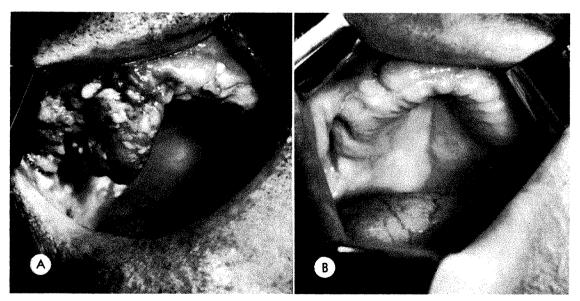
Extensive carcinoma of the left upper alveolus. Treatment was given in 1941 with 400 kv. roentgen rays plus intra-oral cone. (A) Pretreatment. (B) Three months post treatment. The lesion remained healed until the patient died in 1948 from another primary carcinoma.
